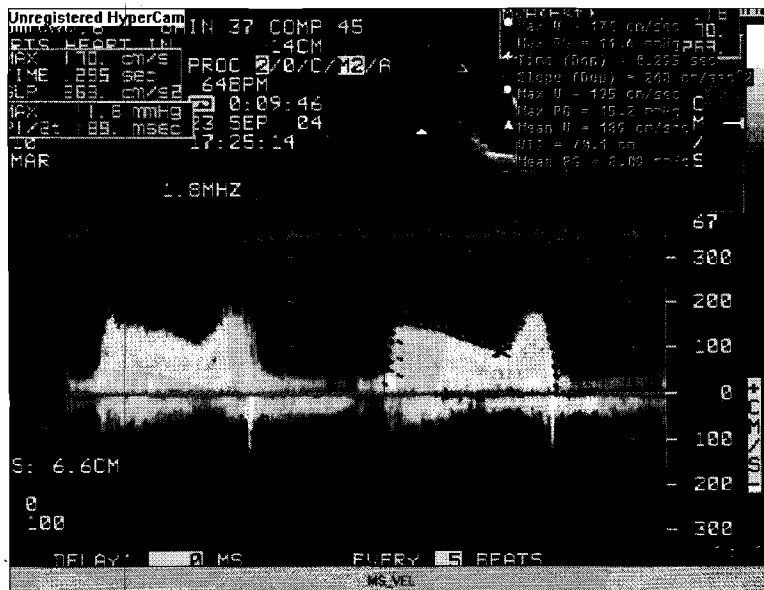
Continuous wave Doppler across mitral valve in-patient of mitral stenosis. The Doppler signal is traced to give peak velocity maximum and mean gradient and pressure half time.
